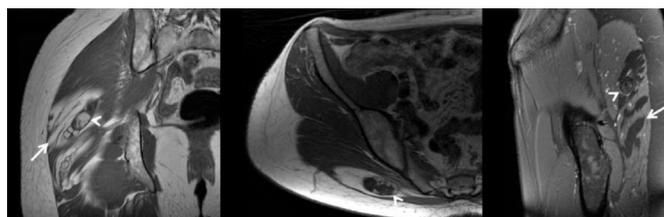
(a) Coronal T1; (b) Axial T1; (c) Sagittal T2 with fat saturation. 30-year-old patient. Previous liposculpture procedure. Patient with a palpable nodule on physical examination. Observe the usual aspect of liposculpture represented by elongated bands with a sign similar to that of fat within the gluteus maximus muscle (arrows). Nodular images within these fat areas show a slightly high T1-weighted signal, with a low-signal halo of peripheral fibrotic tissue, without local edema, representing chronic steatonecrosis (arrowheads).
